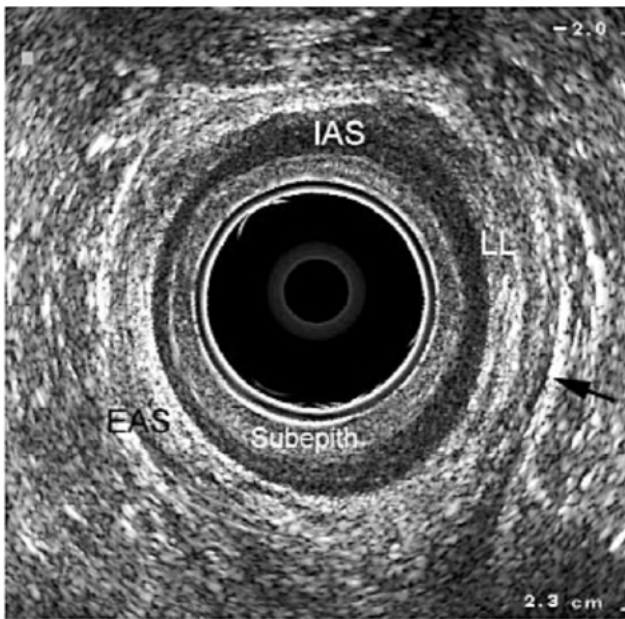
Axial endosonography in the mid canal in a normal 38-year-old female. Subepith: subepithelial layer; IAS: internal anal sphincter; LL: longitudinal layer; EAS: external anal sphincter. The outer border of the external sphincter is defined by an inter- face reflection at the fat/muscle boundary (arrow).
